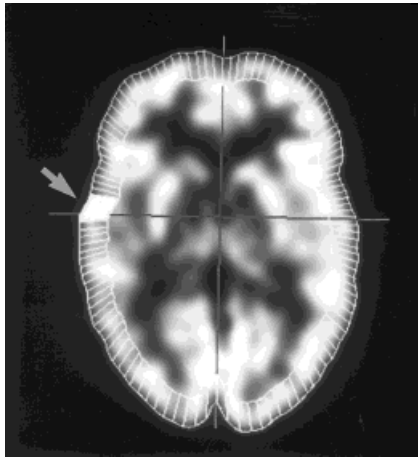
Definition of 60 small homotopic regions in one transaxial plane of an FDG-PET scan. The user can interactively select the thickness of the cortical band. The arrow denotes regions where the asymmetry exceeded a predefined threshold. These regions were marked, allowing the reconstruction of the abnormality in 3-D surface rendered volumes.
